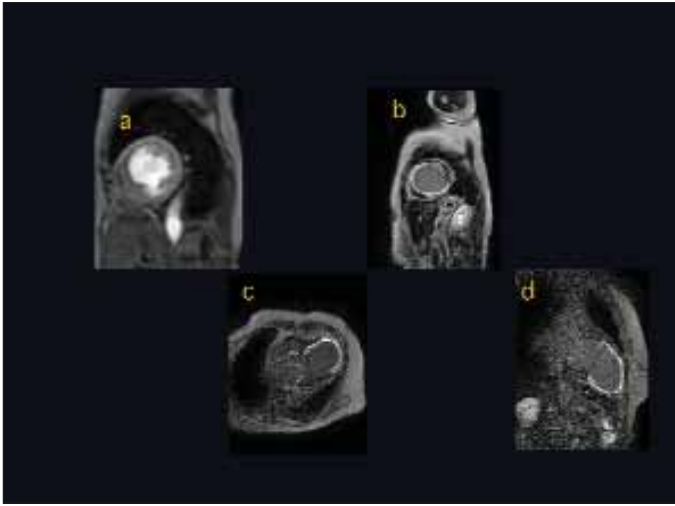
Delayed enhancement cardiac magnetic resonance imaging demonstrating subendocardial first-pass defect a. in the short-axis and multiple hyperenhancement area b. in the short-axis projection, c. 4-chamber projection and d. 2-chamber long axis projection
